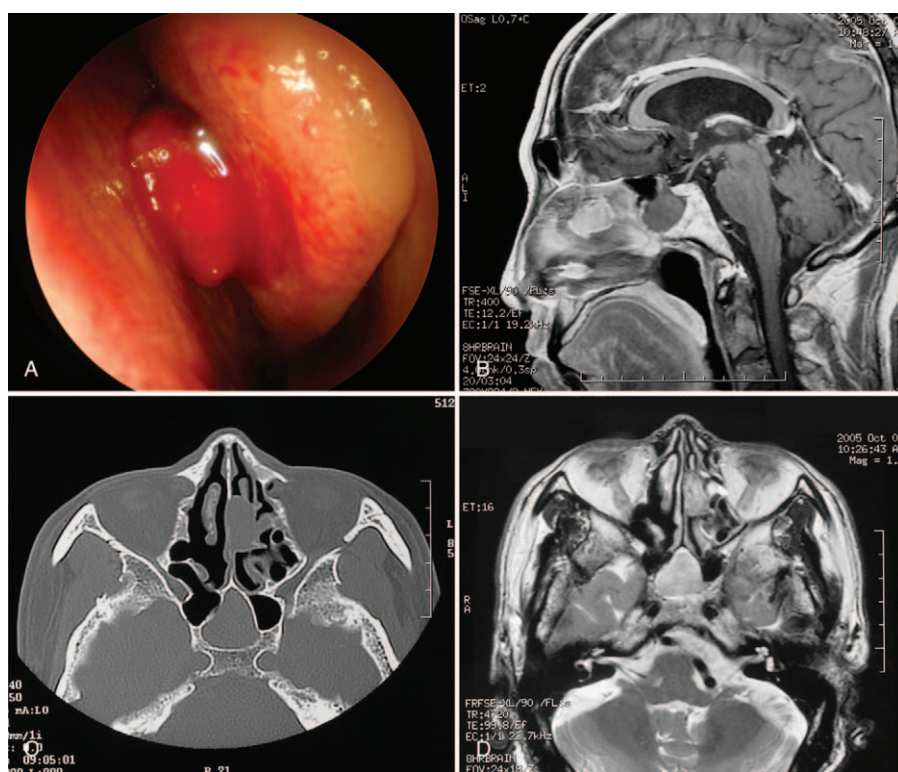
(A–D) ccRCC metastasis to the left olfactory cleft. (A) Endoscopic examination shows a reddish, fragile, hemorrhagic mass on the left olfactory cleft, 1 cm in diameter, and atresia of the right sphenoid sinus. (B) Sagittal MRI of the nasal cavity and paranasal sinus shows a lesion in the left olfactory cleft with a clear, smooth border and heterogeneous density in an enhanced scan, as well as a mucous cyst in the right sphenoid sinus. (C) Axial CT suggests a mass with homogeneous density in both the left olfactory cleft and the right sphenoid sinus. (D) Axial MRI depicts a lesion with a mixed signal based on T2-weighted imaging (T2WI) in the left olfactory cleft and a high-signal lesion in the right sphenoid sinus, with a clear boundary. ccRCC = clear-cell renal cell carcinoma, MRI = magnetic resonance imaging.
